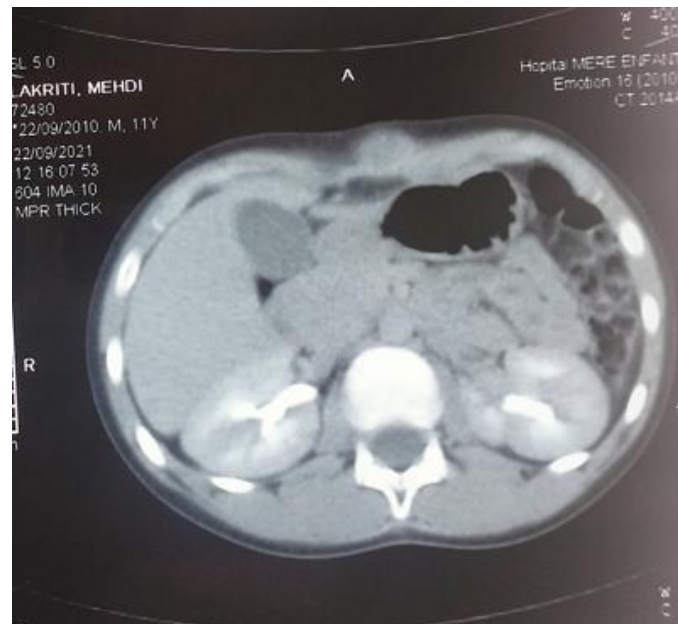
CT scan of a primary mesenteric hydatid cyst in a 13-year-old child
